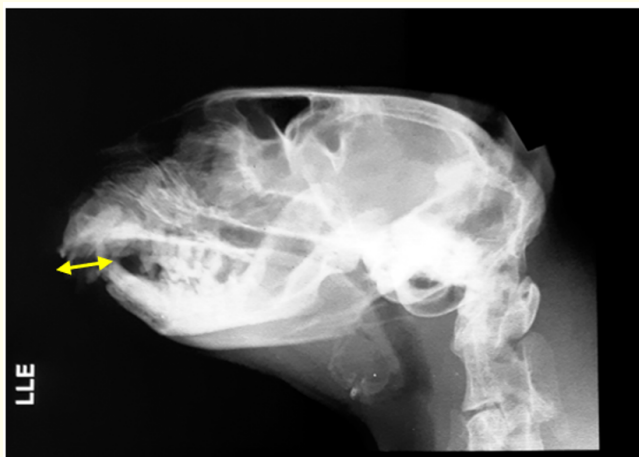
Radiography L/L: mandibular retrognathism and overbite (yellow arrow).
